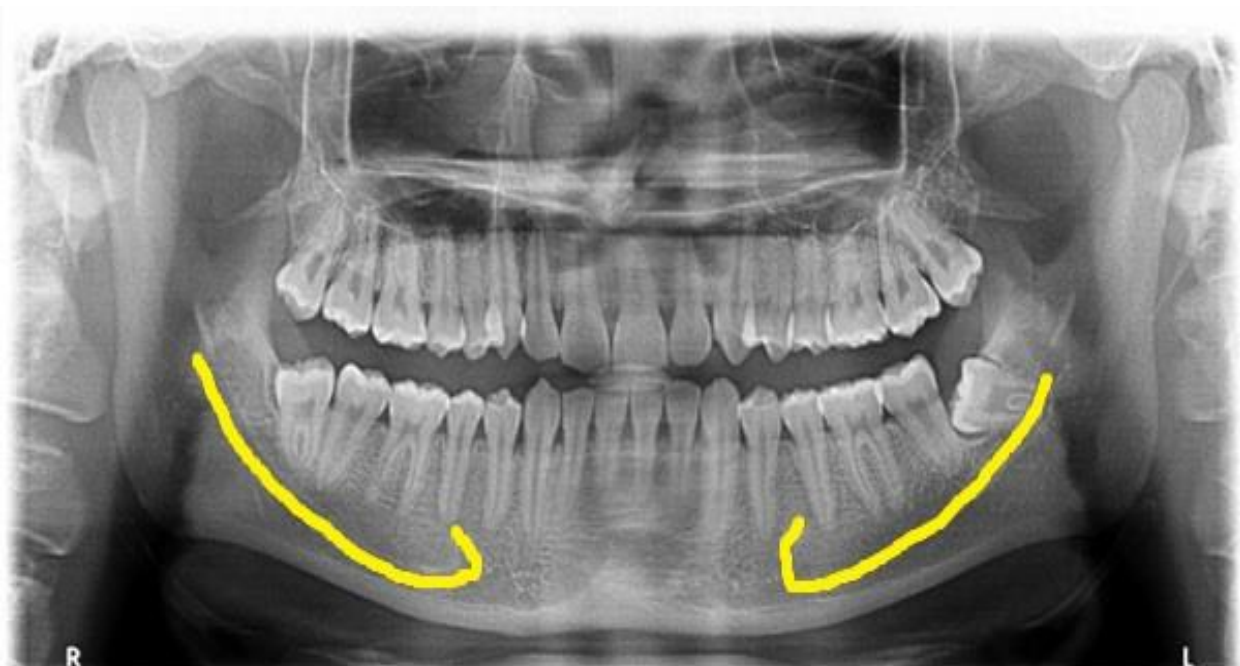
Visibility of anterior loop in Panoramic Radiograph.
